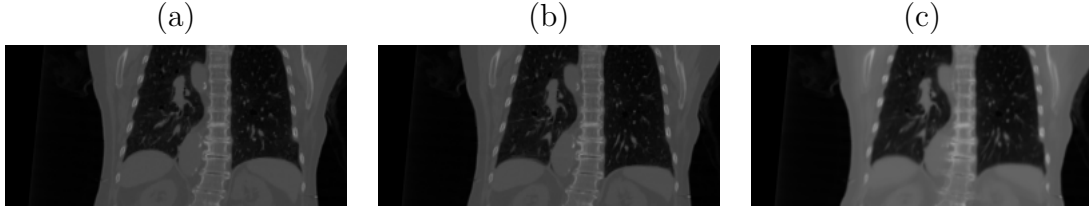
Coronal slices of (a) Respiratory-Correlated CT (RCCT) at the End-Expiration (EE) phase (b) RCCT at the End-Inspiration (EI) phase and (c) Fréchet mean CT generated via the Large Deformation Diffeomorphic Metric Mapping framework from the RCCT dataset.
